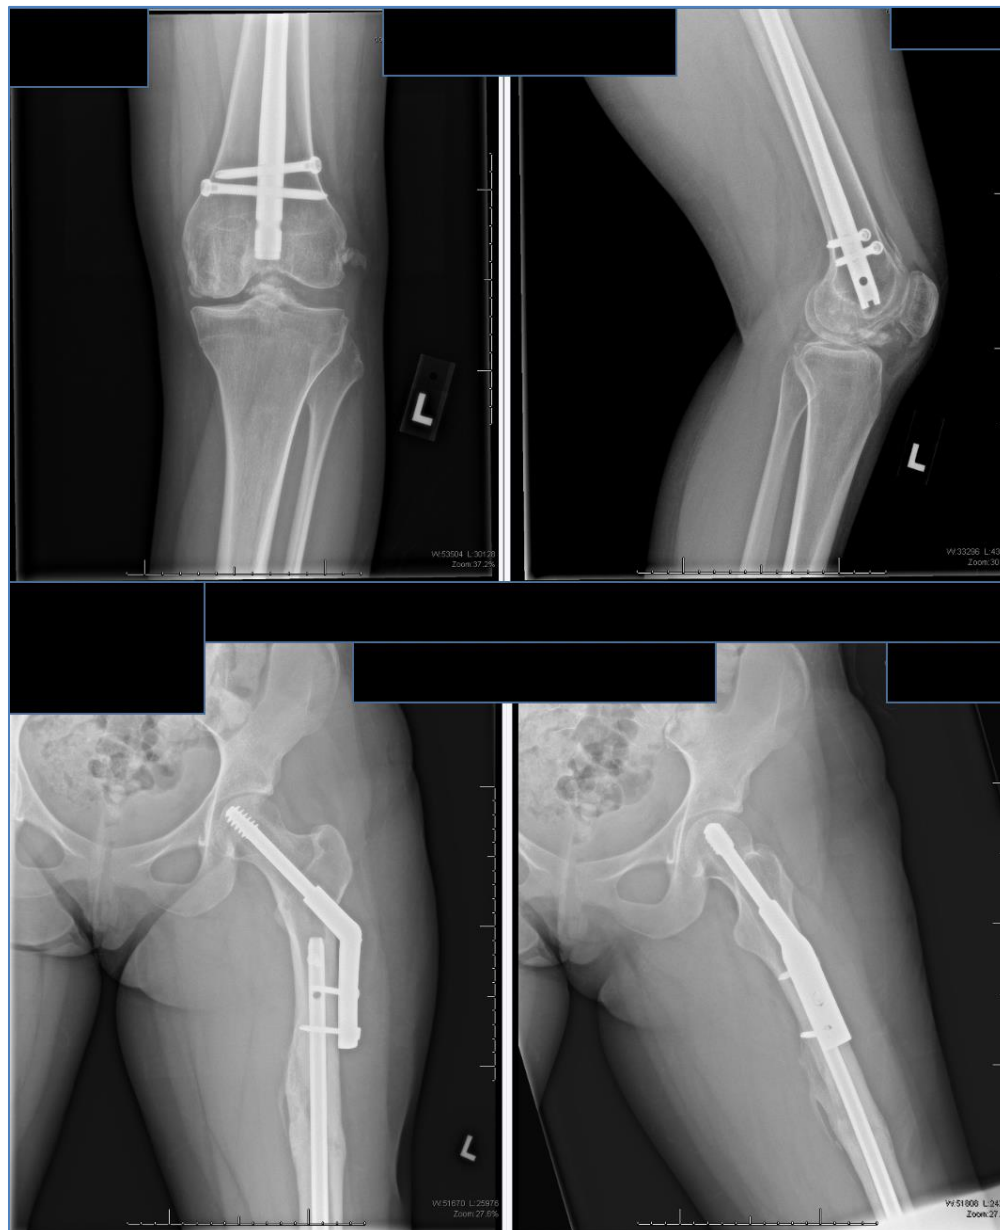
Radiographs of knee and hip one year after initial injury. Top images include an A/P and lateral knee film that indicate H.O. in the intercondylar notch, proximal tibial varus alignment of 9 degrees, opening of the lateral joint space, and bone formation in the lateral epicondyle area consistent with a previous ligamentous injury. Bottom images includes an external and internal rotation hip films that demonstrate proper fracture healing with cortical thickening of the proximal thigh.
